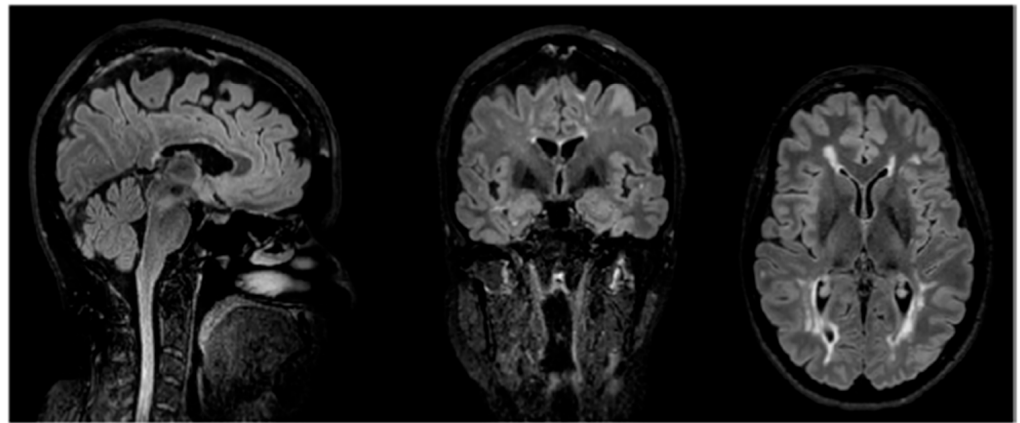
Multiplanar reconstruction of T1 (top), T2 (middle), and FLAIR (bottom) volumetric acquisitions showing multiple demyelinated lesions, confluent posteriorly.
